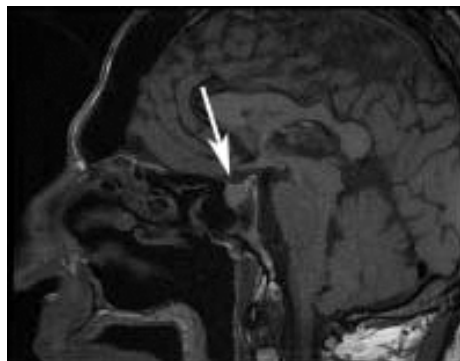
Sagittal T1- weighted MRI image of the pituitary. A tumor (arrow) is visible in and on the sella turcica. The mass is hyperintense compared to the brain parenchyma. The normal posterior pituitary “bright” signal is not seen.
